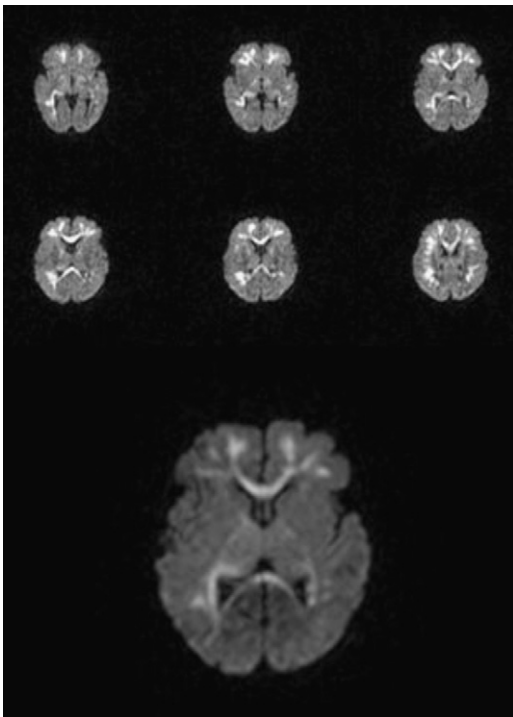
Magnetic resonance imaging (MRI) compatible with encephalitis showing diffuse abnormal diffusion restriction throughout the cerebral white matter tracts in 2 week old infant infected with human parechovirus 3.
